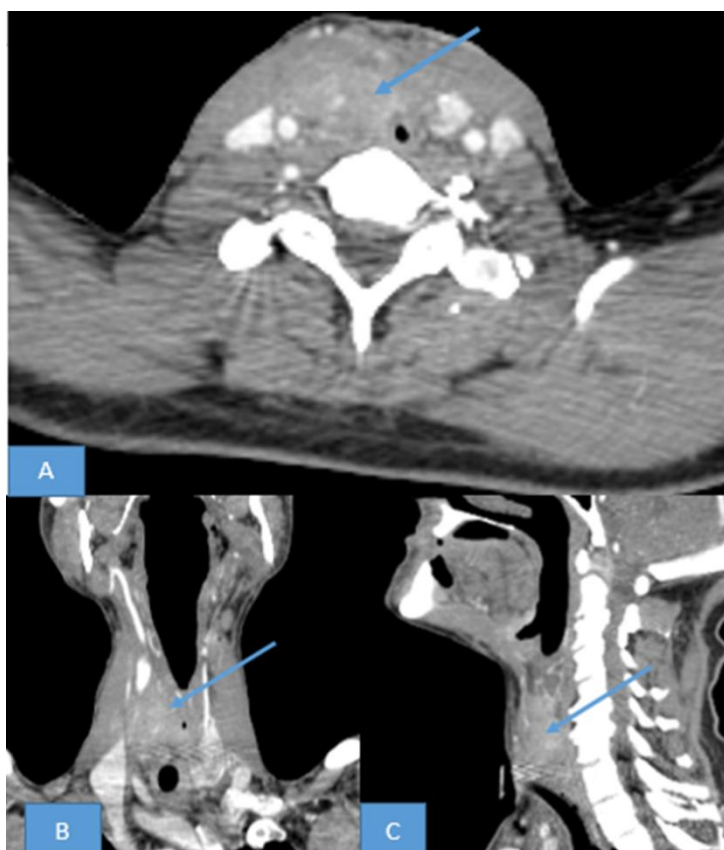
Cervical CT scan, axial (A), coronal (B) and sagittal (C) sections after injection of contrast agent: Tumor process centered on the neopharynx, lateralized on the right, heterogeneously enhanced, encompassing the right common carotid artery and invading the anterior cervical soft tissue (blue arrows), related to tumor recurrence in a 57-year-old patient operated for squamous cell carcinoma of the larynx
